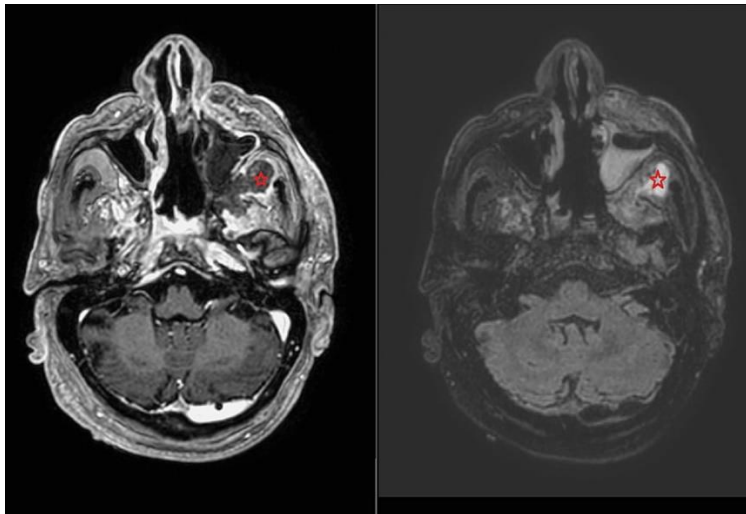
MRI brain for Case 2 (at presentation): The star represents a small collection deep to the left zygomatic arch.
